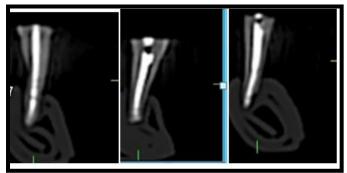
CBCT images of teeth filled with vitapex
